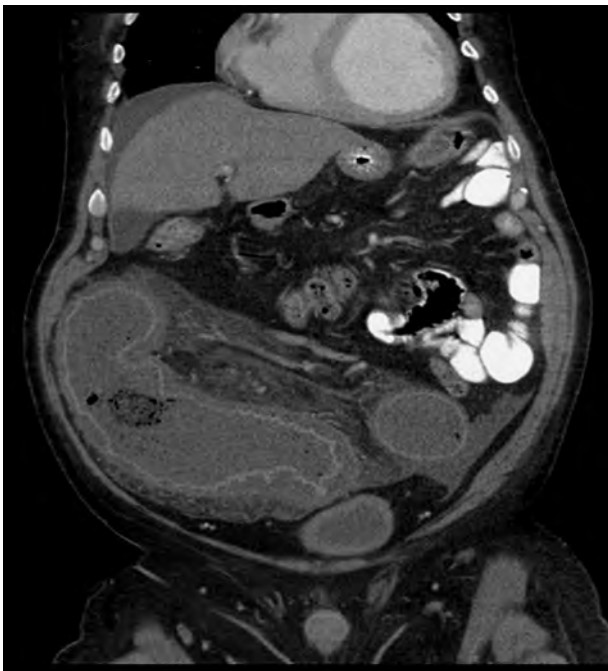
Colitis caused by *Escherichia coli* O157:H7. Coronal reformatted CT scan shows marked mural thickening of a redundant sigmoid colon associated with submucosal edema, inflammatory change in the adjacent mesentery, and ascites.
